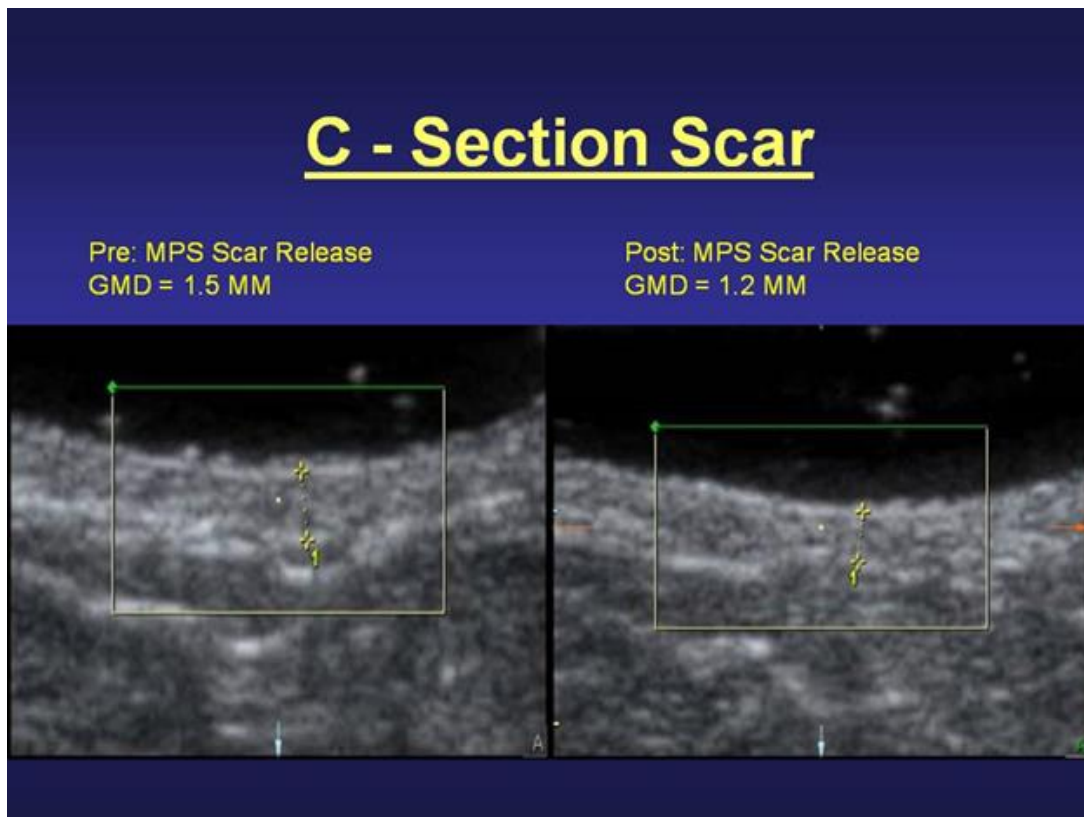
Pre and post ultrasound pictures of a C-section scar after a single treatment. Details of application are as per Figure 1.
